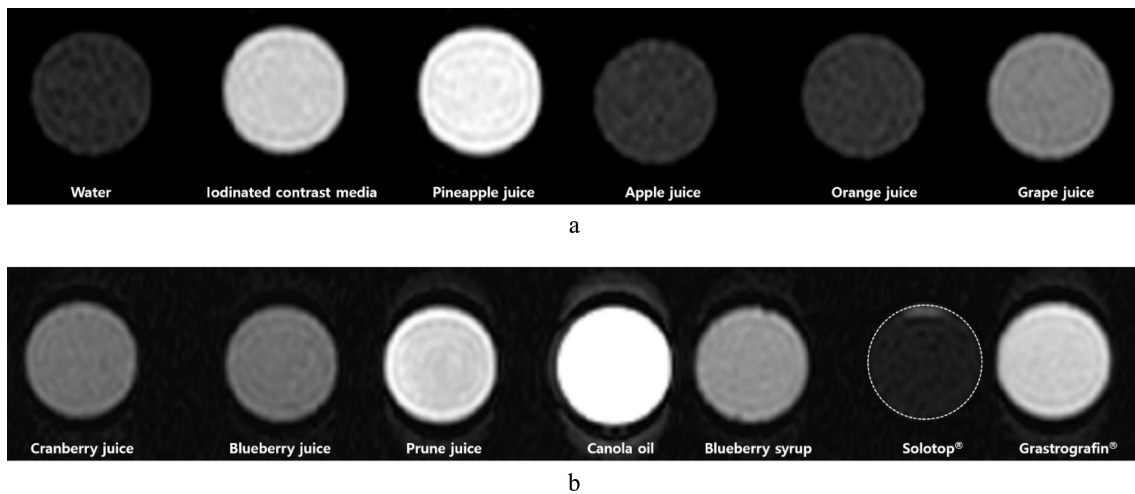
T1-weighted images with contrast media of (a) (left to right) water, iodinated contrast media, pineapple juice, apple juice, orange juice, and grape juice, and (b) (left to right) cranberry juice, blueberry juice, prune juice, canola oil (highest signal intensity), blueberry syrup, Solotop® (circular dotted line), and Gastrografin®.
